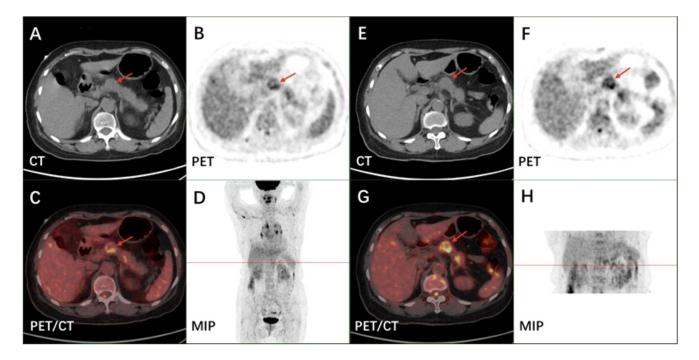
Initial (A–D) and delayed (E–H)¹⁸F–FDG PET/CT: (A, E) transverse CT, (B, F) corresponding PET, (C, G) fusion images showed increased FDG uptake in the pancreatic body, and (D, H) maximum intensity projection (MIP) imaging.
